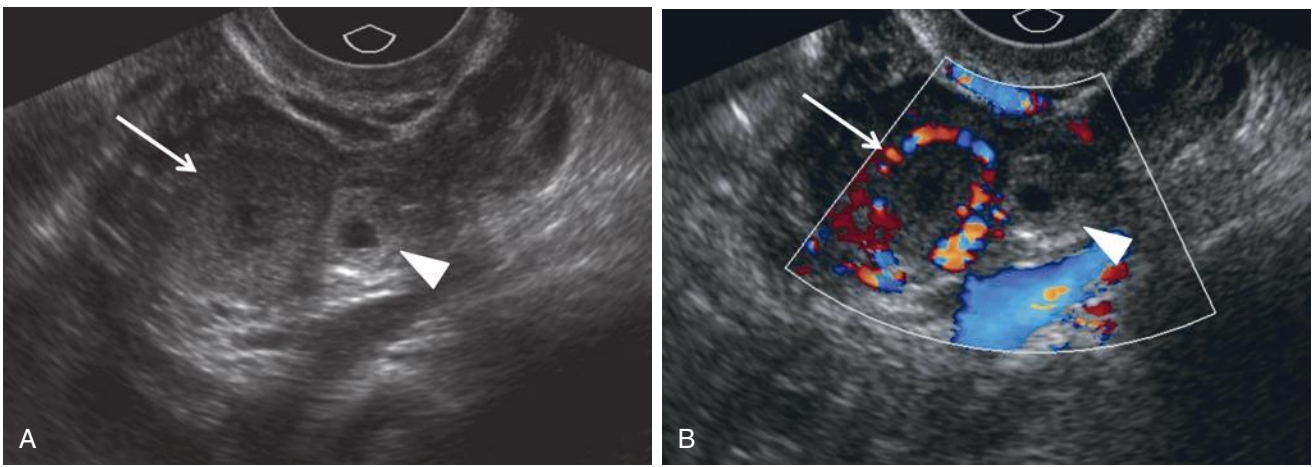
Ectopic pregnancy and ipsilateral corpus luteum with color Doppler ultrasound. A, Transvaginal scan of an ectopic gestational sac (*arrowhead*) and the ipsilateral intraovarian corpus luteum (*arrow*). The ring of the ectopic pregnancy is more echogenic than the rim of the corpus luteum. B, Transvaginal color Doppler scan showing a circumferential vascular “ring of fire” around the corpus luteum (*arrow*) but no flow around the ectopic sac (*arrowhead*). A ring of fire on color Doppler ultrasound is more commonly seen around a corpus luteum than an ectopic pregnancy.
